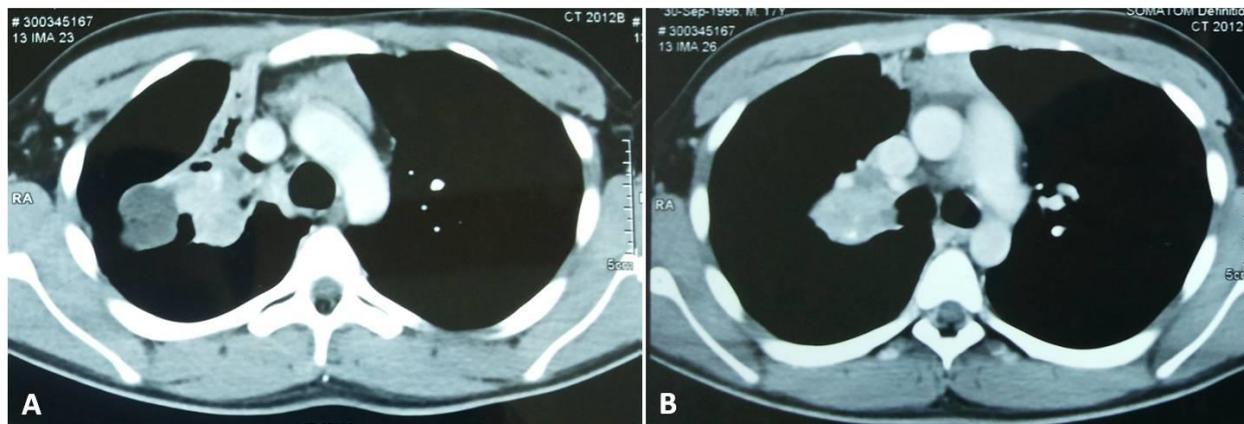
(A)&(B). CT of chest showing mass involving the right upper lobe bronchus with both exo and endobronchial component causing distal obstructive collapse and inspissated secretions in the dilated distal bronchi.
